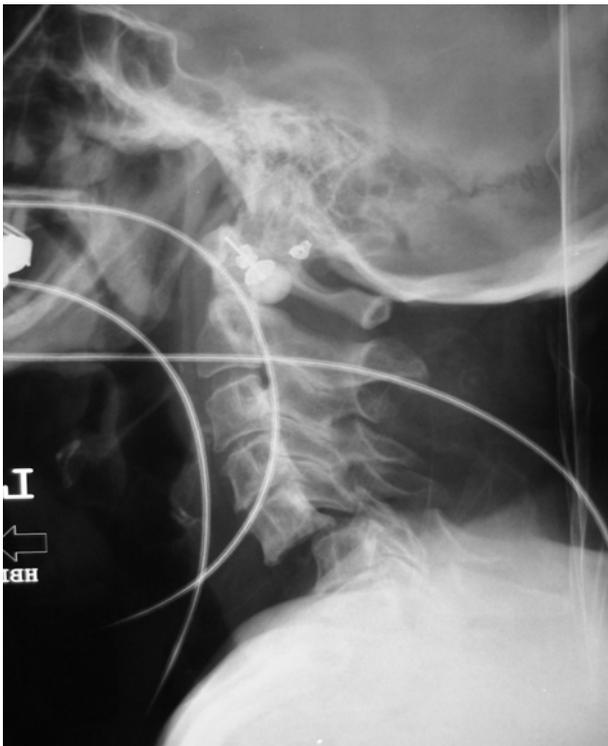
(a). A lateral neck x-ray of a 65 year old woman who had a fall and initially suffered a complete C7 quadriplegia. She was given intravenous methylprednisolone within 2 hours of the injury and haemodynamically resuscitated with immediate recovery of some lower limb function. Initial lateral c-spine x-ray showed bilateral jumped facets at the C5-6 level with approximately 60% subluxation. She was placed into skull traction and with fluoroscopic and neurological surveillance was almost completely reduced with 10 kg of weight.
